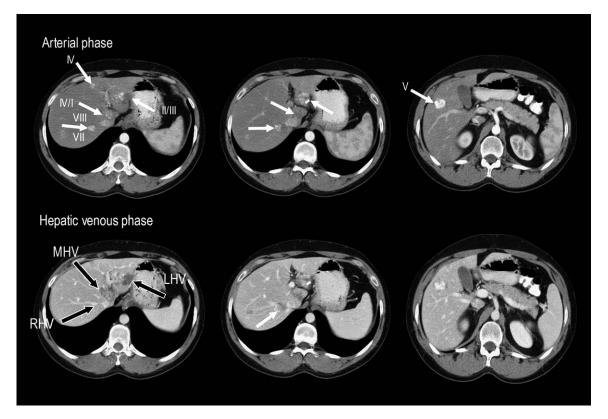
Postchemotherapy triphasic CT scan of the first patient, from January 2004. Colorectal cancer hepatic metastases are indicated by *white arrows*, and the number indicates the hepatic segment that is involved. Each metastasis is only numbered once. The relationship of the metastases to the RHV, MHV, and LHV is indicated by the *black arrows*.
